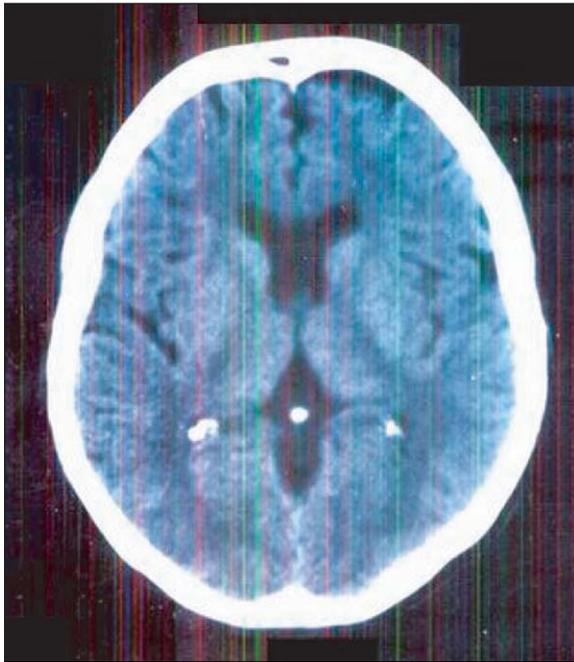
CT Scan of brain showing no intracranial space occupying lesions.
